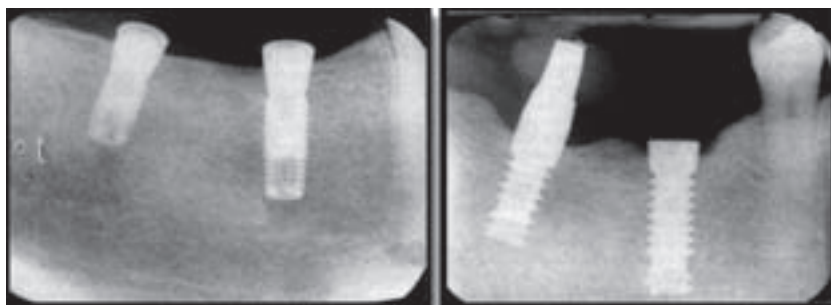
Left: radiograph showing two conical self-tapping Swede-Vent implants which did not osseointegrate; right: wider diameter implants 6 months after immediate replacement of the failed Swede-Vent implants.
